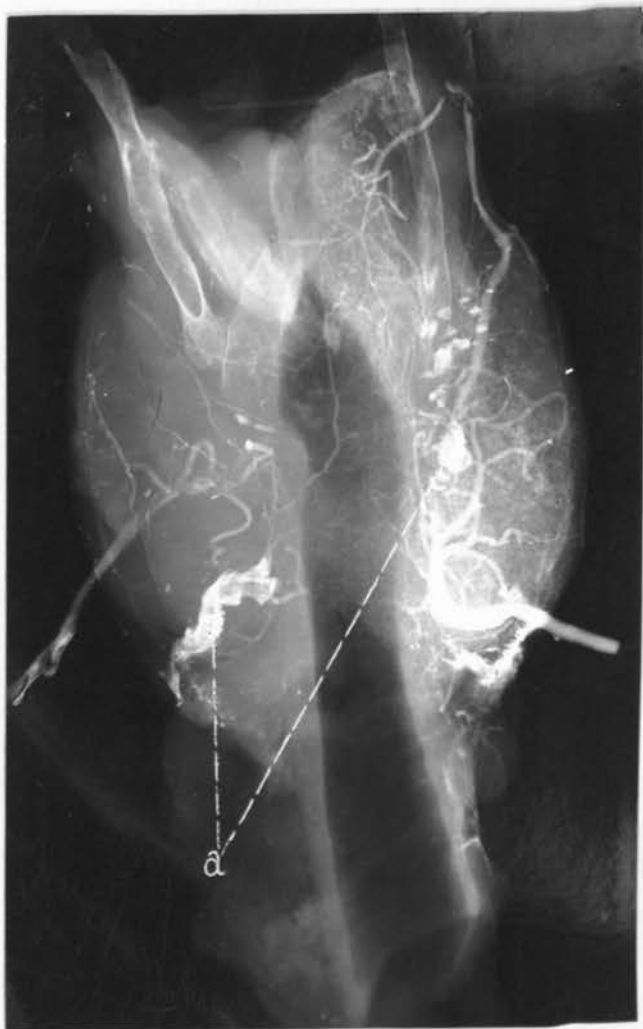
Roentgenogram showing result of injection of right inferior thyroid artery with a carmine, gelatine, bismuth preparation. "a" artefacts.
